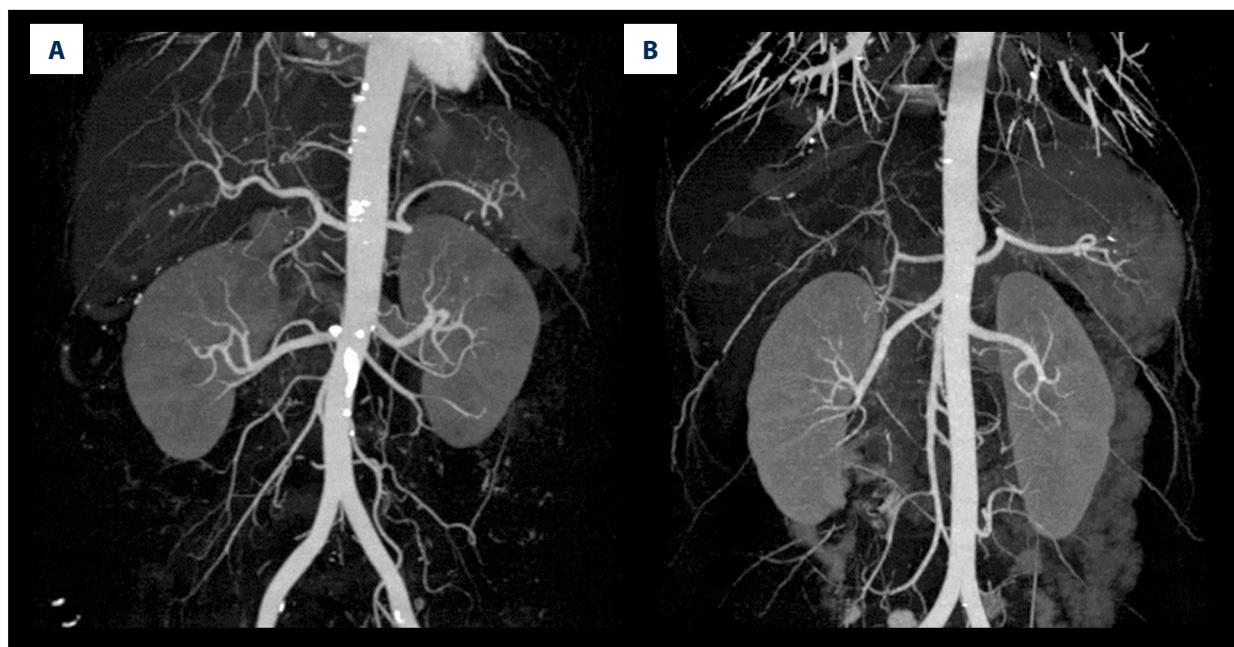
Analysis of MIP images. MIP images were obtained from a 68-year-old man and a 64-year-old woman subjected to the protocols of (A) 120-kVp, iopromide 370 mg/mL and FBP reconstruction and (B) 100-kVp, iodixanol 270 mg/mL and ASIR₁₀ reconstruction, respectively. The CT attenuation values, SNRs, and CNRs at the left renal arteries were 381.53 HU, 17.3, 18.9, and 437.08 HU, 19.2, 21.1, respectively.
